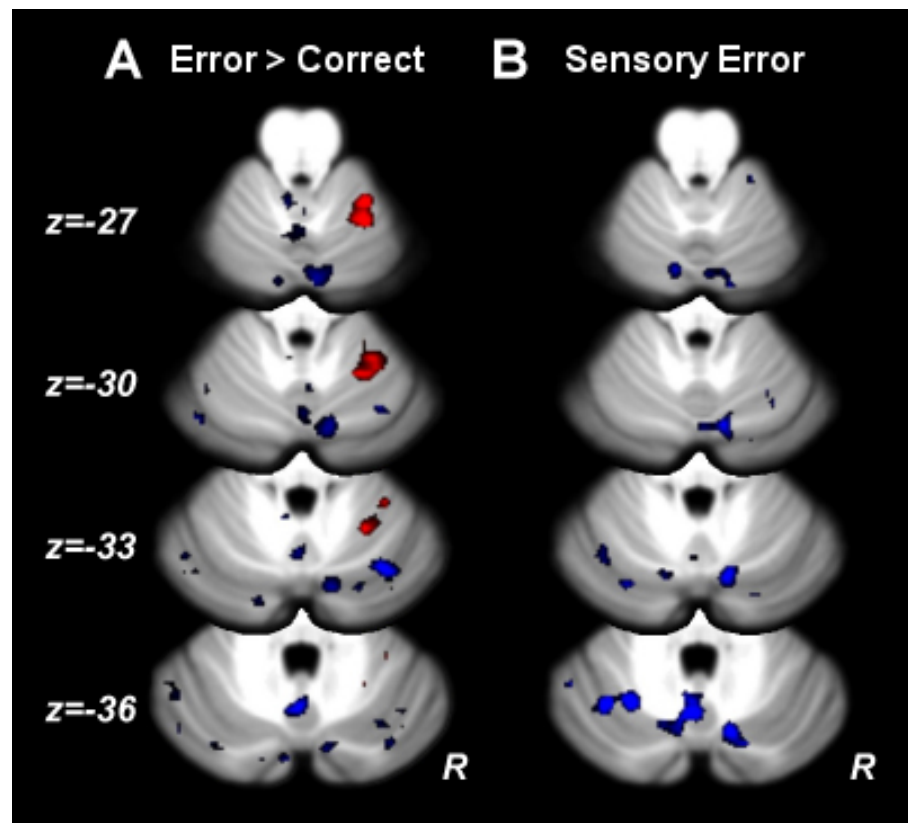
MRI after heartrate correction. A) The effect of errors. Shown in red is the region in Right Lobule V that is more active during error trials than during correct trials. In blue are regions more active for correct trials than error trials. B) Errors conveyed by a sensory signal. In blue are regions more active during trials in which no sensory stimulus was present, or an expected sensory stimulus was present, compared to trials in which the sensory stimulus conveyed an error signal. Once again, no regions are selectively active during trials in which the sensory stimulus conveys the error.
